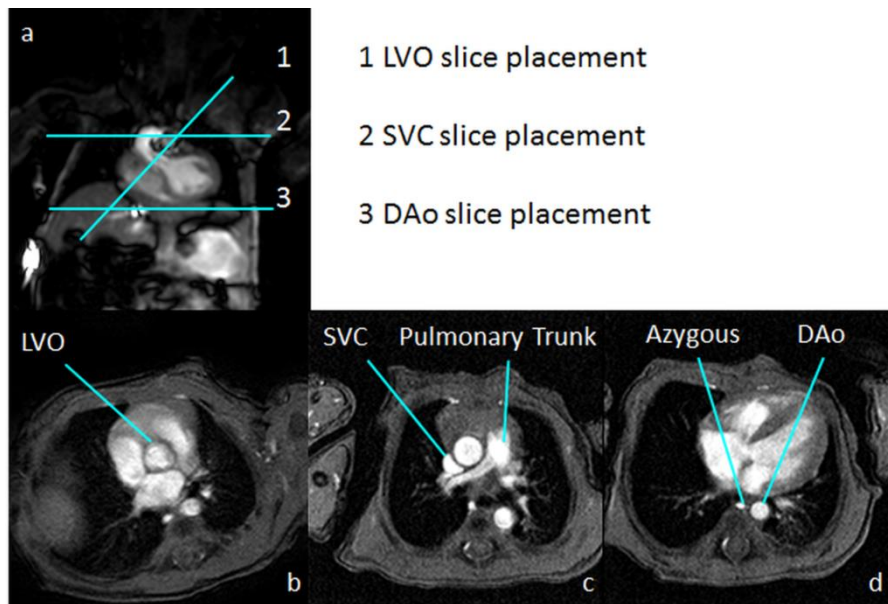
Study design: a: Anatomical position of the 3 PC MRI sequences. PC MRI sequence to quantify b: LVO, c: SVC flow volume and d: DAo flow volume. PC MRI sequences were acquired during free breathing. Images show no significant respiratory motion artefacts.
